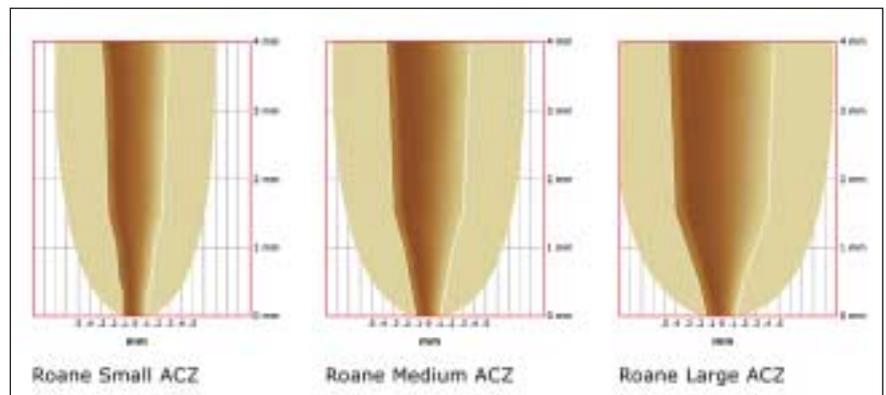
Roane defined his small, medium and large apical capture zones as #45, #60 and #80 preparations. The parameters he established were; small ACZ, #15 file to the radiographic terminus (RT), #45 file 1.5 mm back from the terminus, medium ACZ, #20 file to the RT, #60 file 1.5 mm back, large ACZ, #25 file to the RT, #80 file 1.5 mm back.
